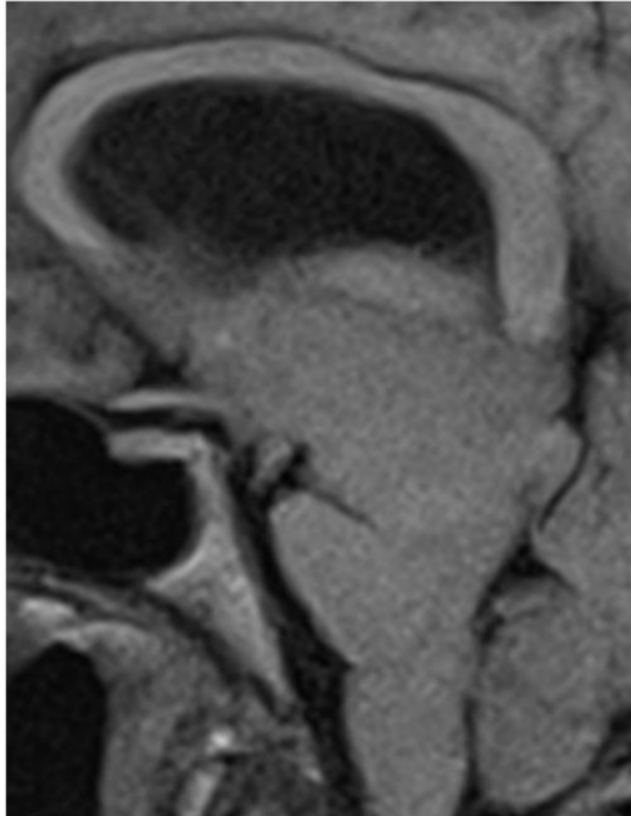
Normal brainstem anatomy on sagittal MRI (left) compared to severe brainstem sagging from SIH (right)
